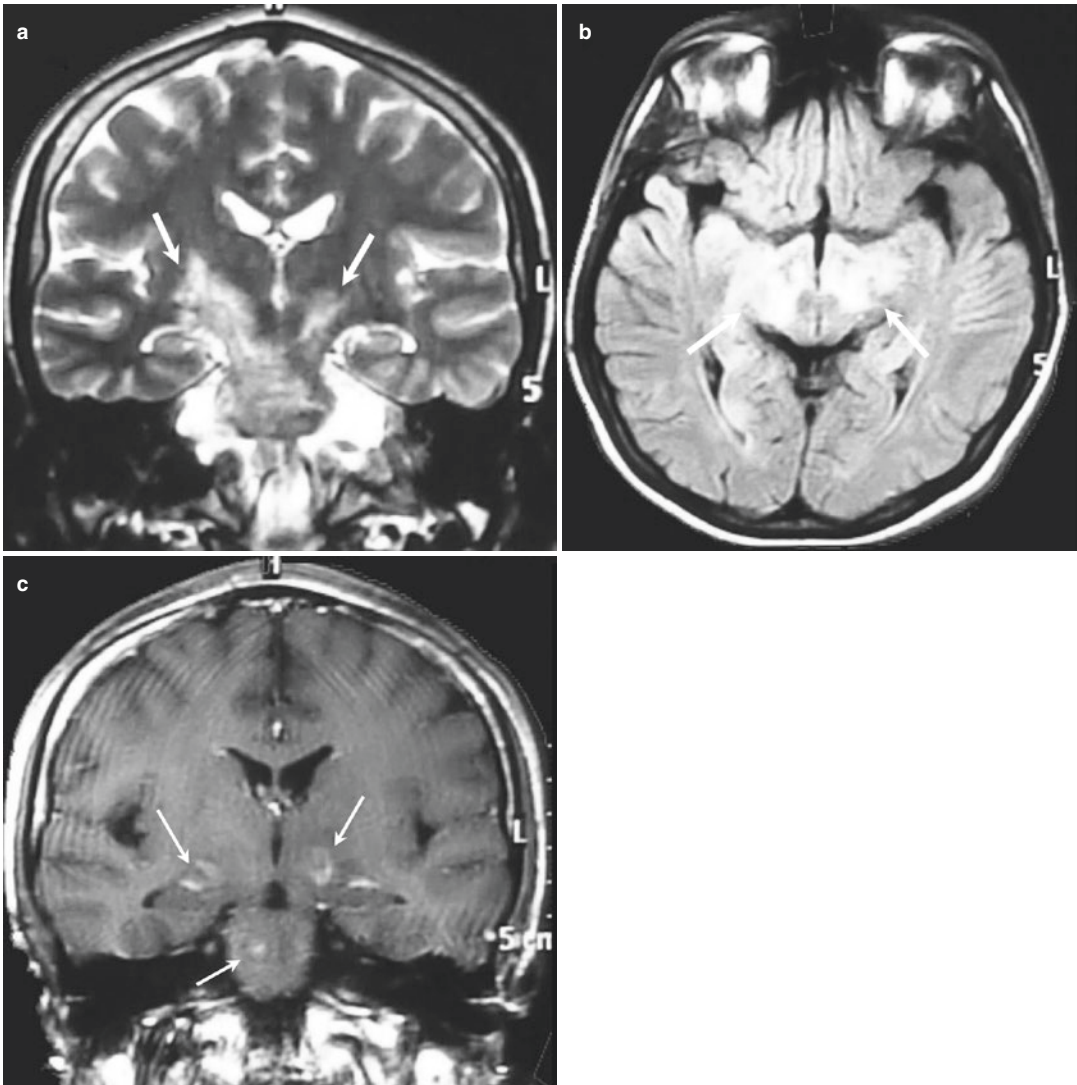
Parenchymal neurologic involvement (arrows indicating the locations of the lesions) (Courtesy of Professor Murat Kürtüncü). (a) Coronal T2 weighted image of the patient. The bilateral lesion extends from the thalamus to mesencephalon (b) Axial FLAIR weighted
